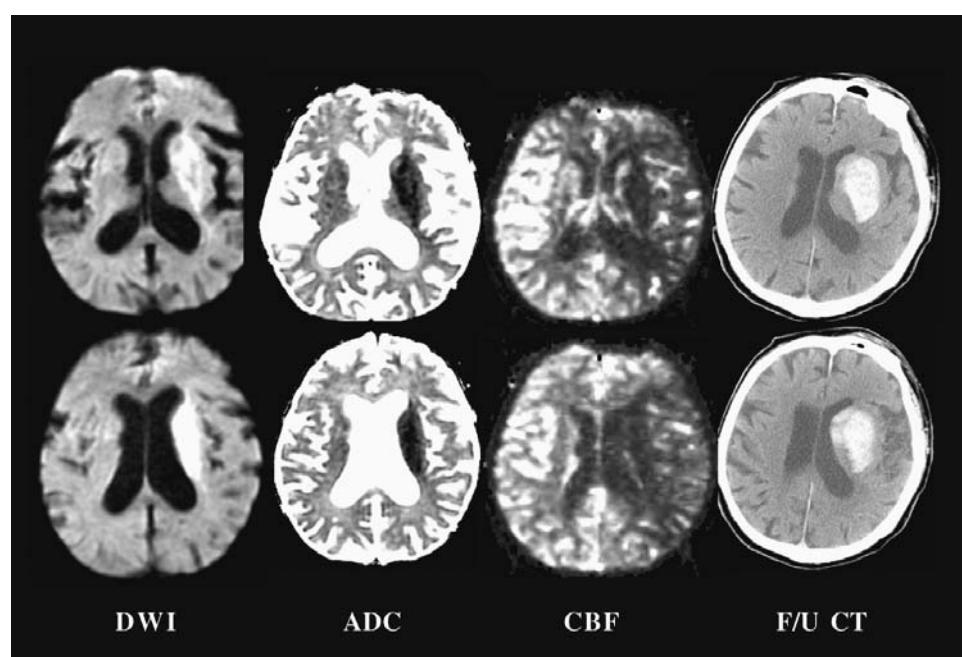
Acute ischemic stroke with hemorrhagic transformation. Seventy-three-year-old male with right hemiplegia, treated with IA tPA. There is an acute stroke (DWI hyperintense, ADC hypointense) involving the left basal ganglia, anterior limb of internal capsule, and corona radiata. Note the profound reduction in ADC and CBF in these regions where there is hemorrhagic transformation on follow-up CT. CBF images also demonstrate less severely reduced CBF in most of the left MCA territory. *Abbreviations:* tPA, tissue plasminogen activator; DWI, diffusion-weighted images; ADC, apparent diffusion coefficient; CBF, cerebral blood flow; MCA, middle cerebral artery.
